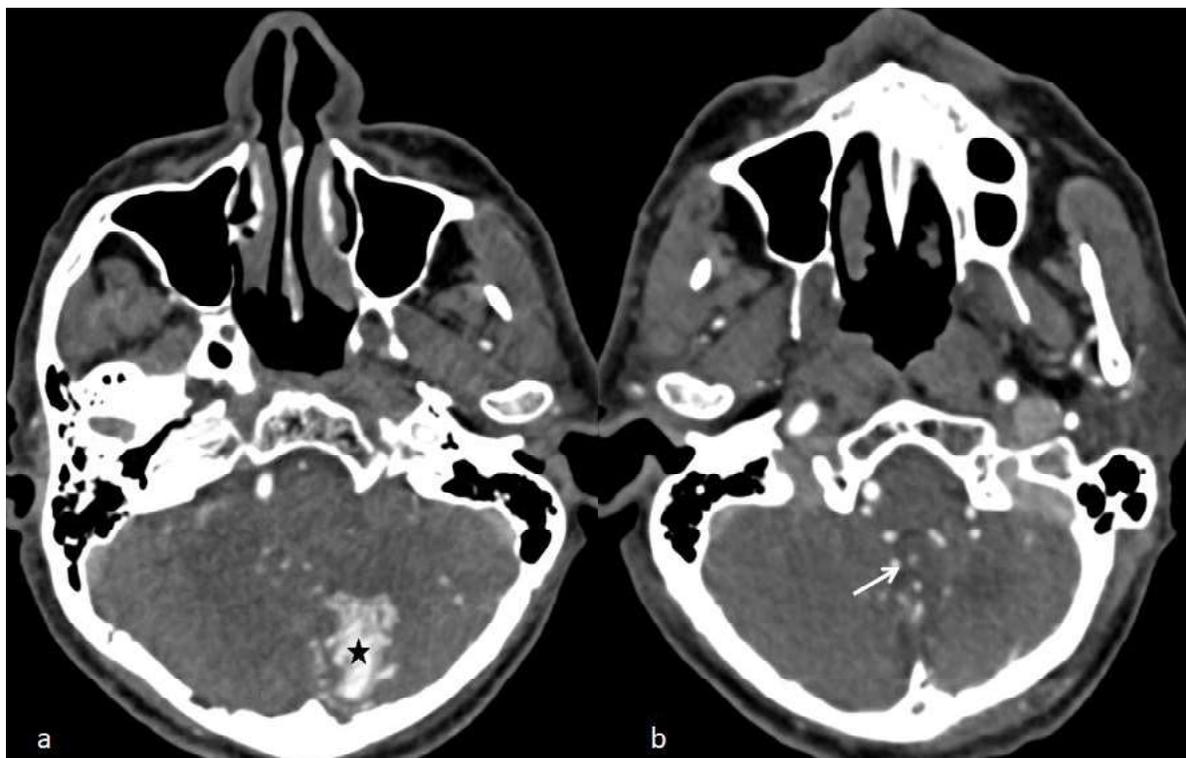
(a,b): Post-operative CT Angiography axial images showing reduction in size of nidus (asterisk) with non opacification of flow related aneurysm (white arrow).
